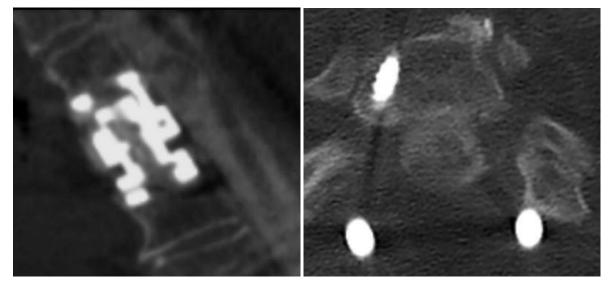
Pre-operative CT myelogram of the thoracic spine a) sagittal b) axial. Seen again is a persistent mass ventral to the spinal cord displacing the cord posteriorly.
